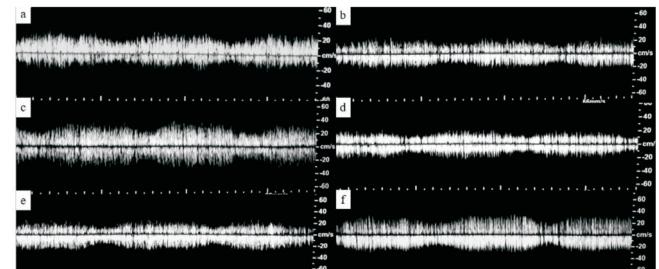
(a) Proximal artificial cerebral blood flow dopplergrams in 25% vasodilation; (b) distal artificial cerebral blood flow dopplergrams in 25% vasodilation; (c) proximal artificial cerebral blood flow dopplergrams in 50% vasodilation; (d) distal artificial cerebral blood flow dopplergrams in 50% vasodilation; (e) proximal artificial cerebral blood flow dopplergrams in 75% vasodilation; (f) distal artificial cerebral blood flow dopplergrams in 75% vasodilation.
